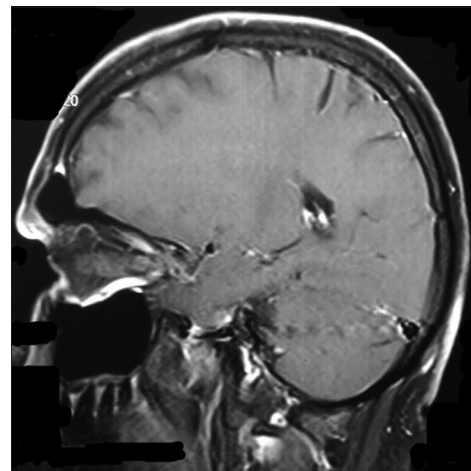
Sagittal MRI Brain
